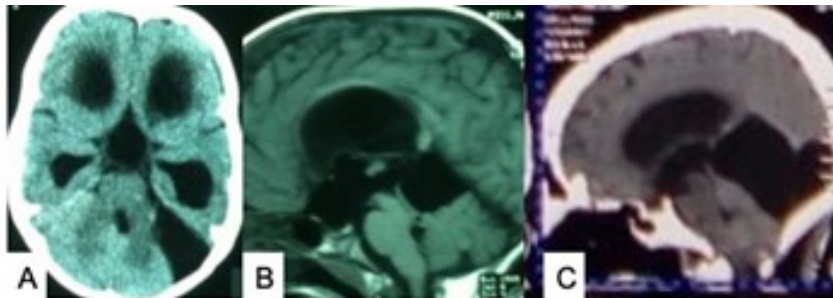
(A) CT shows CP angle arachnoid cyst with HCP. (B) MRI shows pineal region arachnoid cyst with HCP. (C) MRI shows huge pineal region arachnoid cyst with HCP. Source: Figure by authors.
